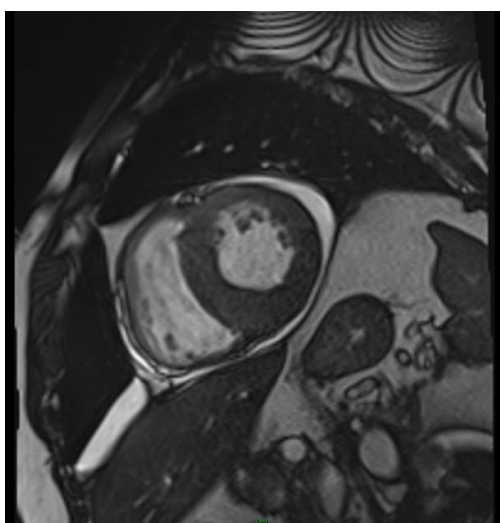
Cardiac magnetic resonance imaging showing severe thickness of interventricular septum (left), and late gadolinium enhancement with increased diffuse subendocardial signal at the basal segments of the left and right ventricles and interatrial septum
